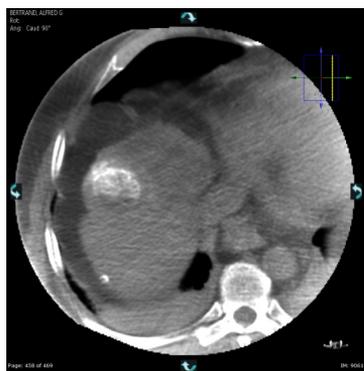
Completion non-contrast CBCT performed during DEB-TACE via the middle hepatic artery. There is marginal contrast saturation of the anterior portion of the target tumor (white arrow) within segment IV corresponding to the region of residual disease in Figure 3. The posterior, previously treated portion of the tumor is hypoattenuating compared to normal liver parenchyma (black arrow).
